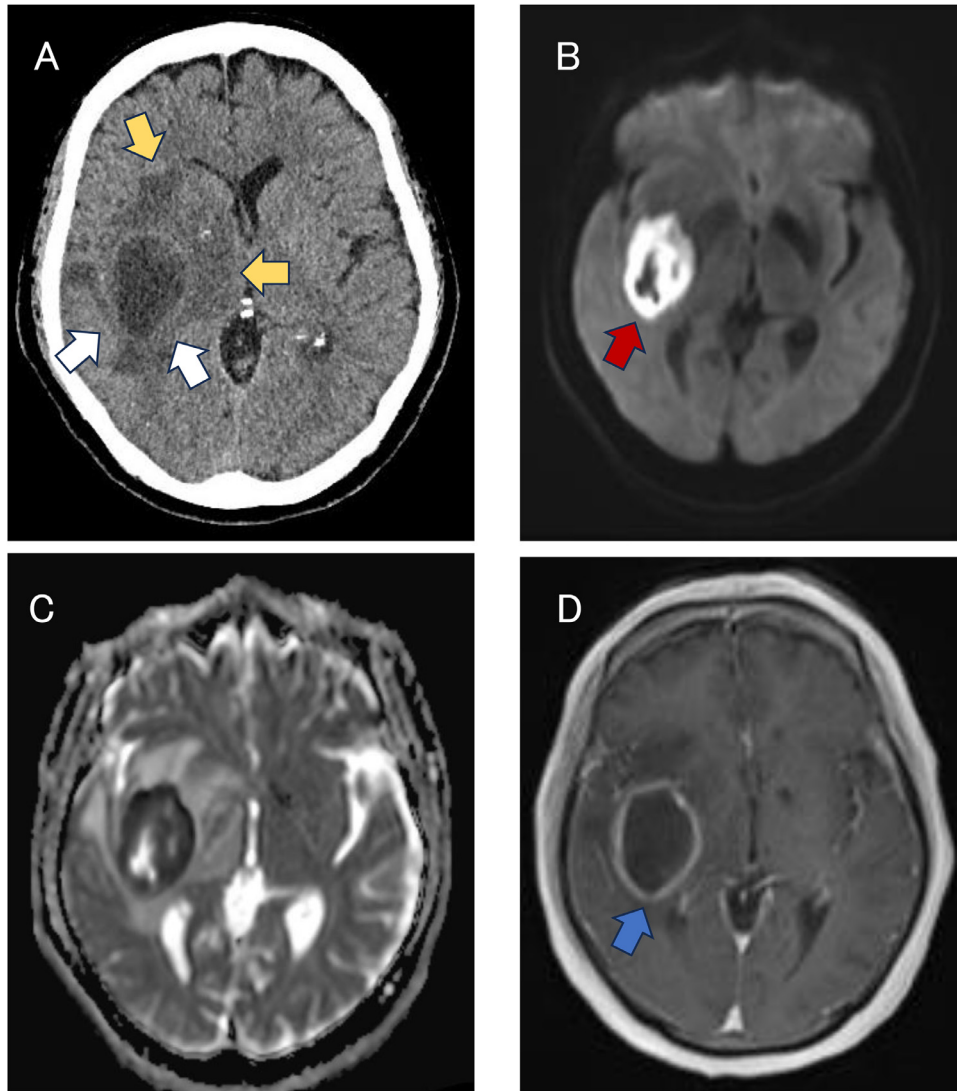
Images at the brain abscess onset. (A) Axial noncontrasted head computed tomography images show a low-density region (white arrows) with surrounding edema (yellow arrows) on the lateral side of the right lentiform nucleus. (B) Axial diffusion-weighted magnetic resonance images show very high signal intensity in this region (red arrow). (C) The corresponding apparent diffusion coefficient map. (D) Axial gadolinium-enhanced T1-weighted magnetic resonance images show ring-shaped enhancement in this area (blue arrow).
